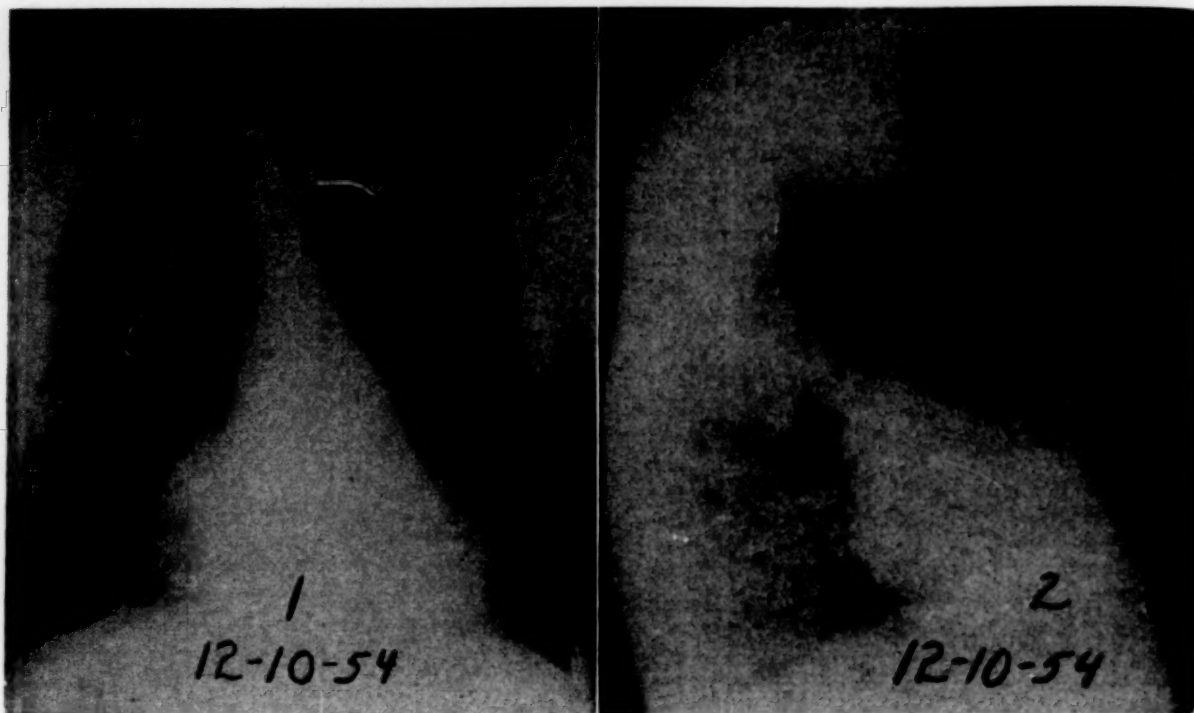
CASE VII. Preoperative roentgenograms. Note thin-walled bullae on right with compression of hilar structures.
